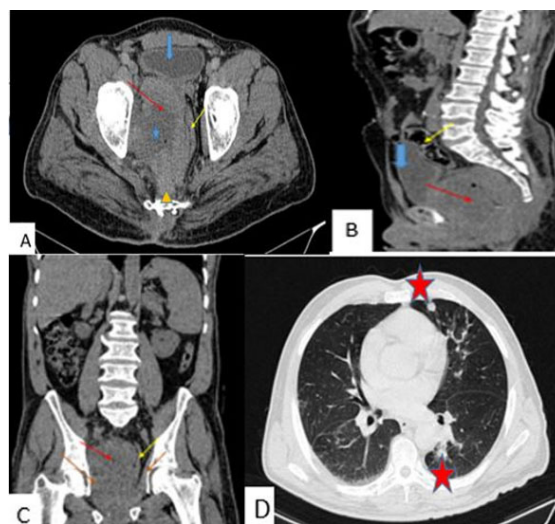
Abdominal CT: axial C+ section (A) sagittal and coronal section C-, (B, C) pelvic retroperitoneal multilobulated mass (red arrow) with necrotic area (blue star) exerting a mass effect on the rectum in the left (yellow arrow), on the anal canal below, on the bladder anteriorly (blue arrow), and on the obturator internus muscle laterally (orange arrow) with persistent fatty separation axial section in the pulmonary parenchymal window. (D) Metastatic pulmonary nodules in the lower left lobe (red star).
